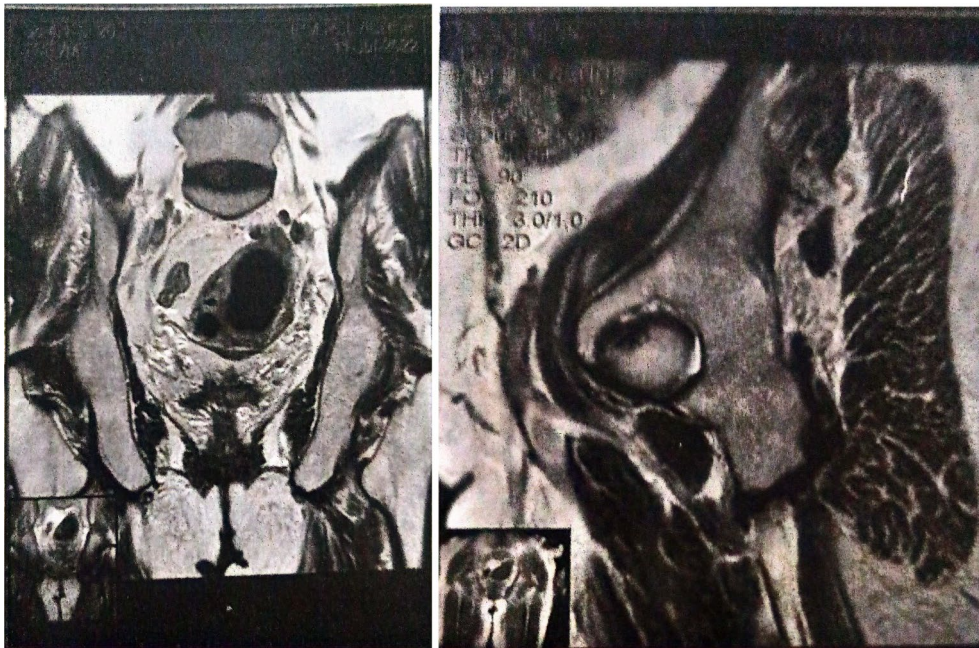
Abdominal–pelvic magnetic resonance imaging showed a solid cystic left ovarian mass classified as Ovarian-Adnexal Reporting and Data System 5
